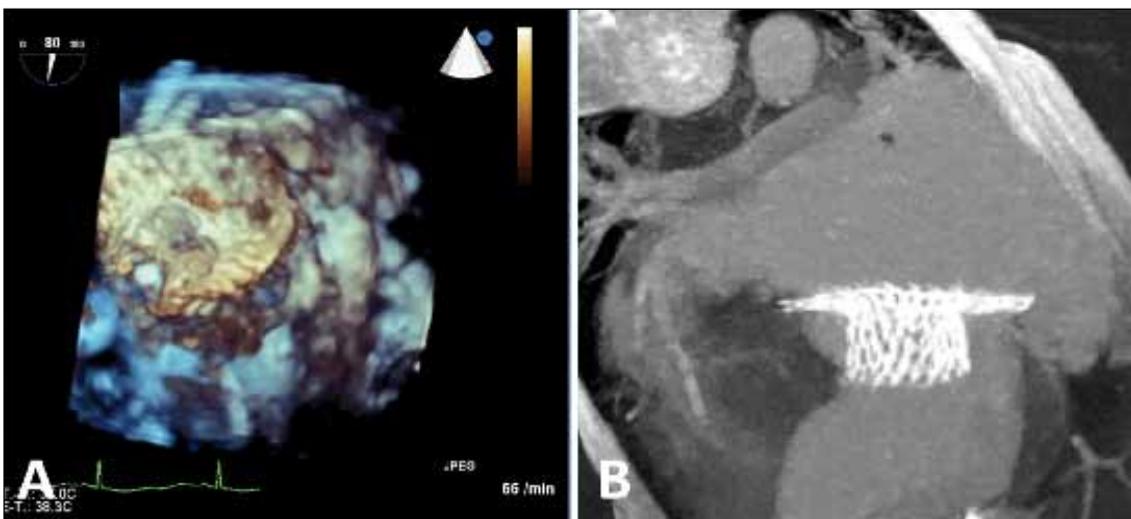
A: 3D transesophageal echocardiographic image showing the valved stent after successful deployment in the native mitral annulus during systole. B: 3D reconstruction from cardiac computed tomographic data showing correct position of the valved stent within the native mitral annulus.
